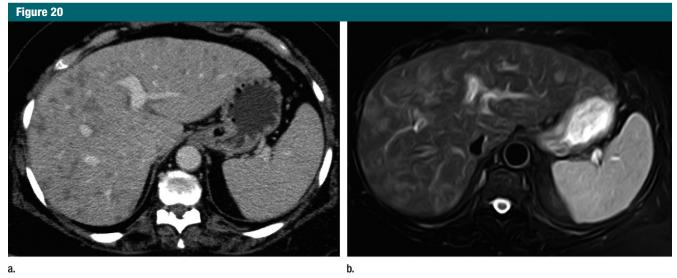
Images in a 70-year-old woman with pseudotumoral sarcoidosis. (a) The liver is unremarkable at arterial-phase contrast-enhanced CT (not shown) while multiple ill-defined low-attenuation lesions are seen at portal venous phase CT. (b) Fat-suppressed fast SE T2-weighted MR image (2500–8000/90; flip angle, 90°; section thickness, 4 mm) shows multiple moderately hyperintense liver lesions.
